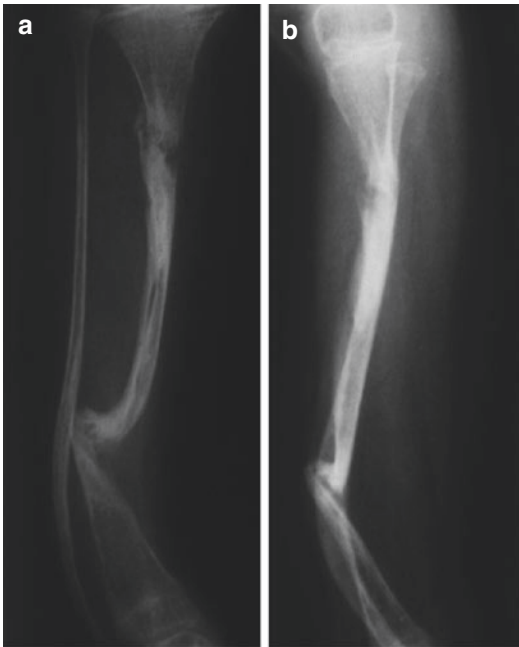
Dysplastic congenital tibial pseudarthrosis without fibular pseudarthrosis (type IV). (a) Anteroposterior and (b) Lateral X-ray of the right lower leg
